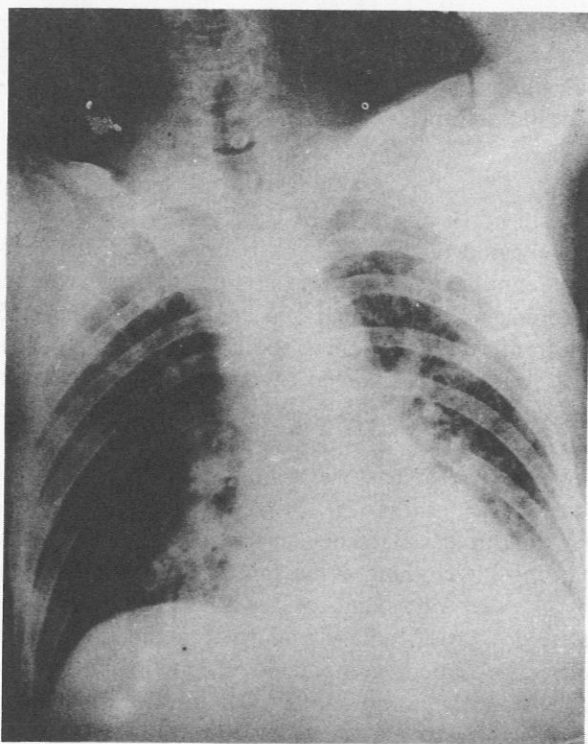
X-Ray Film of the Chest Taken with a Portable Apparatus Sixteen Hours after the Accident.*
